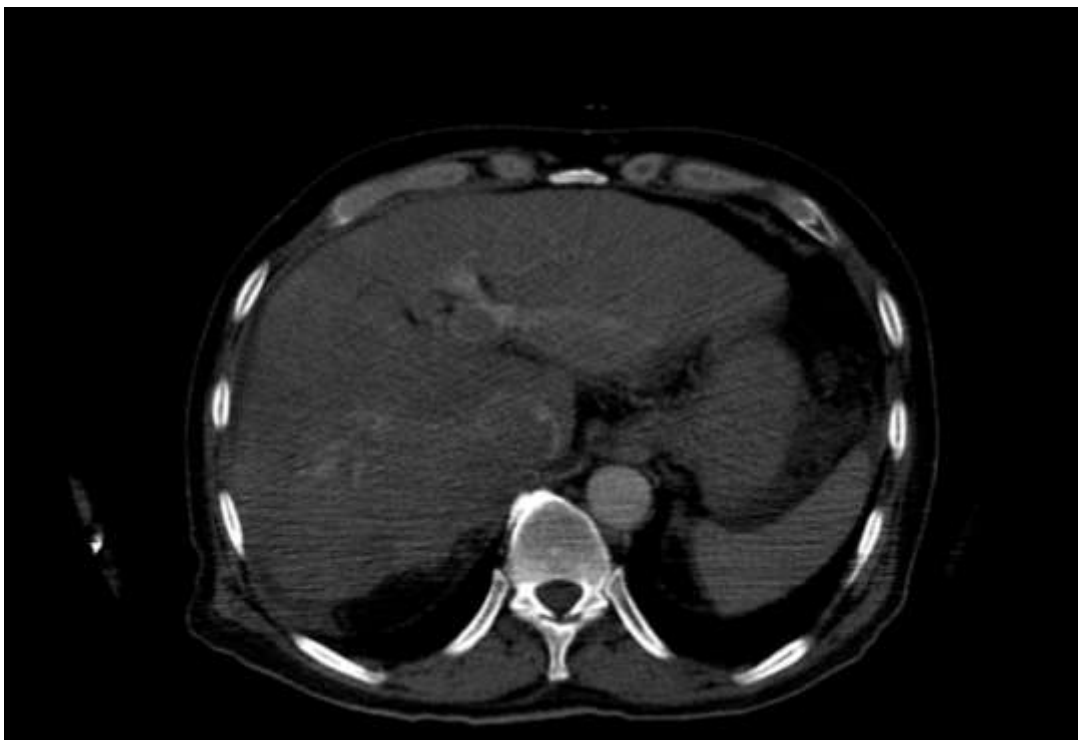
Axial contrast-enhanced CT image demonstrating altered hepatic enhancement and/or direct hepatic invasion related to the right adrenal mass and portal venous tumor thrombus.
